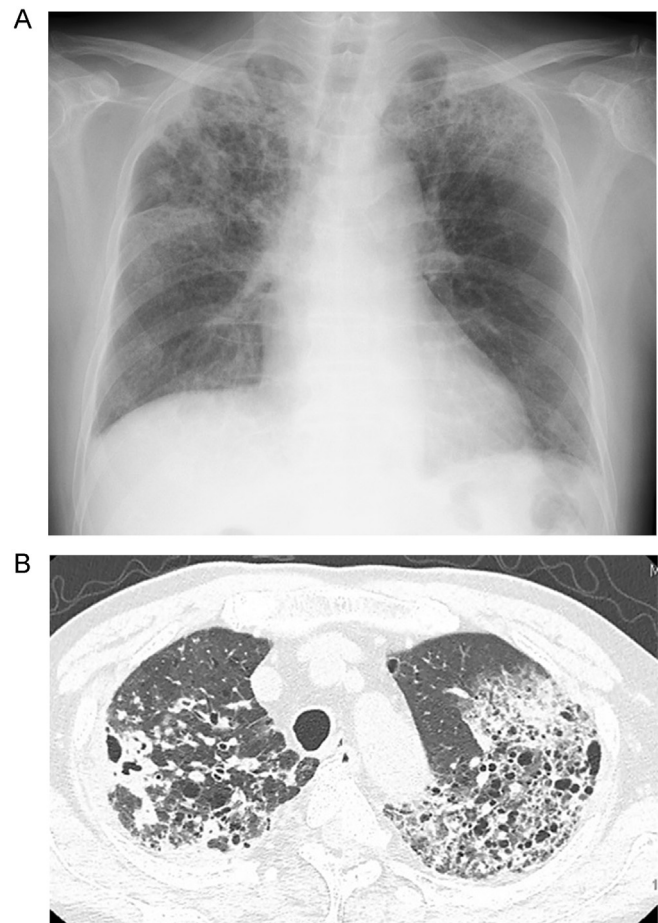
(A) Chest X-ray shows exacerbation of the consolidation in the right upper lung field and the spread of consolidation to the left upper lung field. (B) Chest computed tomography shows the spread of consolidation in the bilateral lung lobes.
